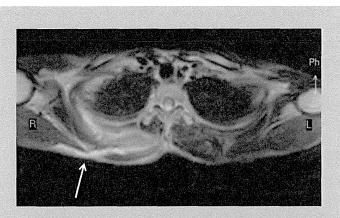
MRI taken when difficulty in right shoulder elevation occurred. MRI shows a T2-high intensity lesion in the right scapular region (subcutis to tunica muscularis, arrow).
